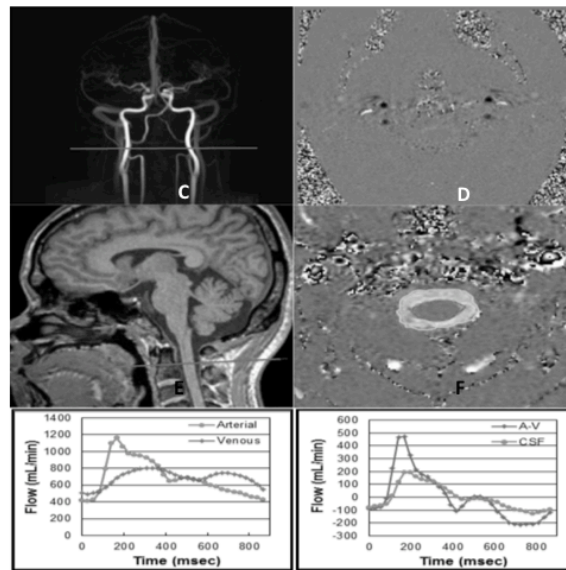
MRI method. *A.* A blood vessel MRI scout image showing the location of the axial plane for blood flow measurement (horizontal line). *B.* A Phase Contrast MRI image of blood flow through that location of carotid arteries, vertebral arteries and jugular veins. Black pixels indicate arterial inflow and white are venous outflow. *C.* Anatomical mid-sagittal T1 weighted MR image showing the location of the axial plane used for CSF flow measurement (horizontal line). *D.* MRI images of the region of interest for CSF flow: the spinal canal (light grey) and the spinal cord (dark grey). *E-F.* MRI-based measurements of arterial inflow, venous outflow (*E*), and cerebrospinal fluid flow (*F*) used for derivation of the MRICP with derived waveforms of the total arterial inflow and venous outflow (*E*) and CSF flow and arterial minus venous (*F*) during the cardiac cycle (with permission from Alperin et al.).
